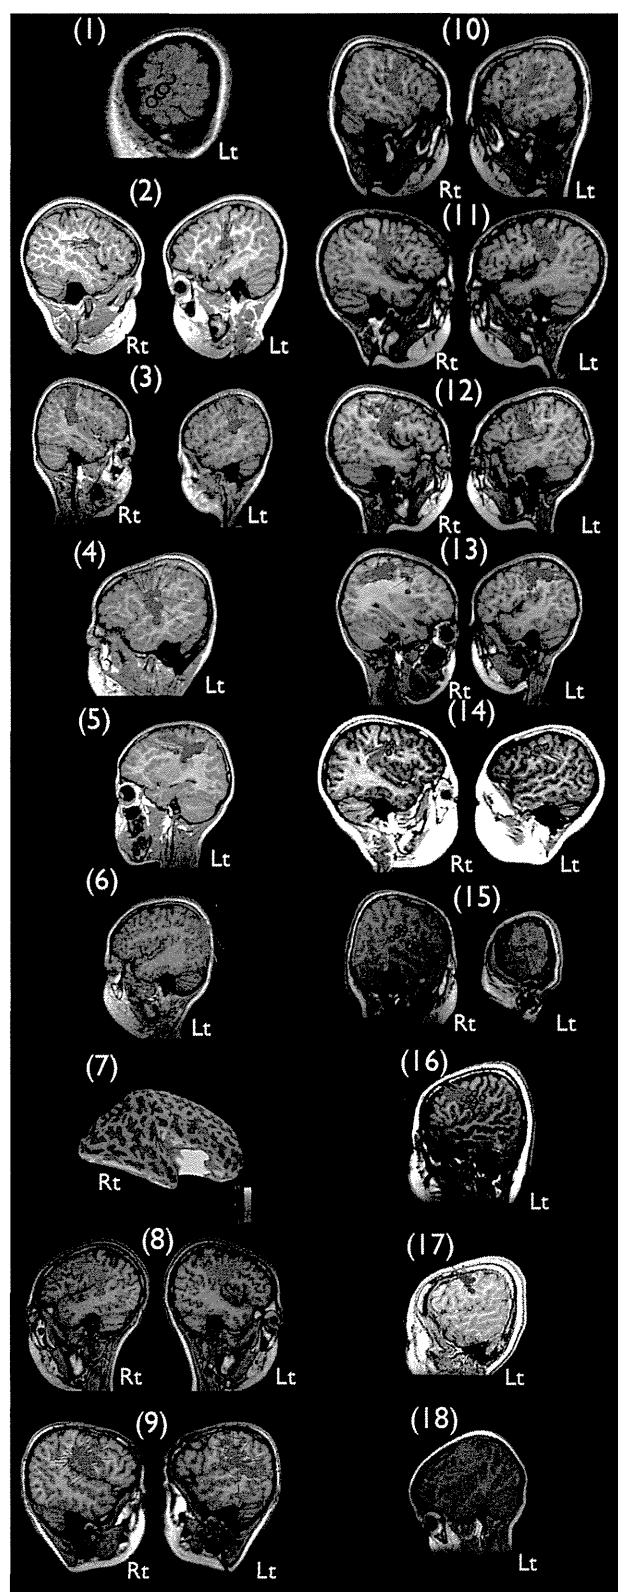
MRI with MEG spike sources in 18 cases. Red circles demonstrate the source of MEG spikes. Tails indicate orientations and moments of the MEG spike sources. Case 7 shows dynamic statistical parametric mapping. The color bar indicates the P value, ranging from gray, 1×10^{-1} to yellow, $1 \times 10^{-4.3}$. (For interpretation of color in Fig. 1, the reader is referred to the web version of this article)
